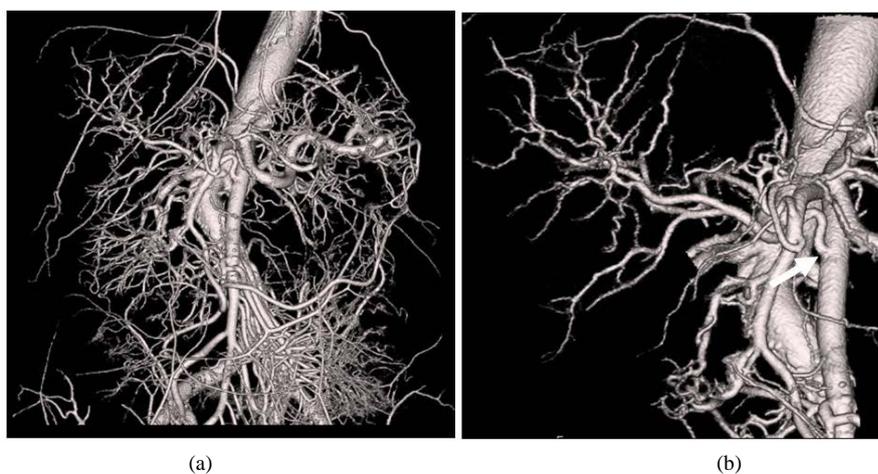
A 46-year-old woman with gallbladder adenomyomatosis. (a) The high-quality CT arteriography clearly shows small arteries of the abdominal viscera; (b) This CT arteriography image only depicts the right hepatic artery. CT arteriography clearly shows the right hepatic artery arising from the superior mesenteric artery (white arrow) and small cystic artery and sub segment hepatic arteries.
